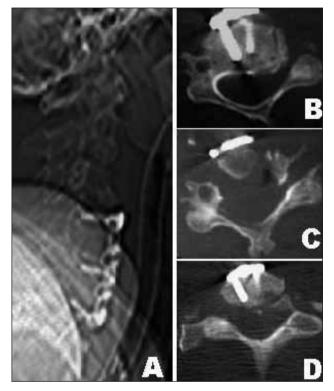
(A, B, C, D) Postoperative computed tomography views. During surgery, corpectomy of the infected vertebra with epidural abscess drainage (C5, C6 and C7 corpectomy), iliac crest bone grafting and anterior cervical instrumentation in between C4-T1 were performed.
